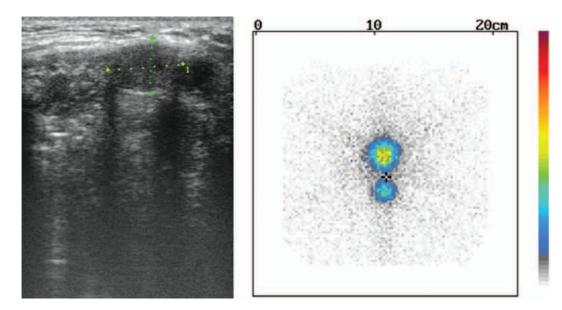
Ectopic lingual thyroid in a patient with congenital hypothyroidism. A. Ultrasound picture. B. confirmation by scintiscan Rycina 17. Ektopowa tarczyca językowa u pacjenta z wrodzoną niedoczynnością tarczycy. A. Obraz ultrasonograficzny. B. Potwierdzenie w badaniu scyntygraficznym
